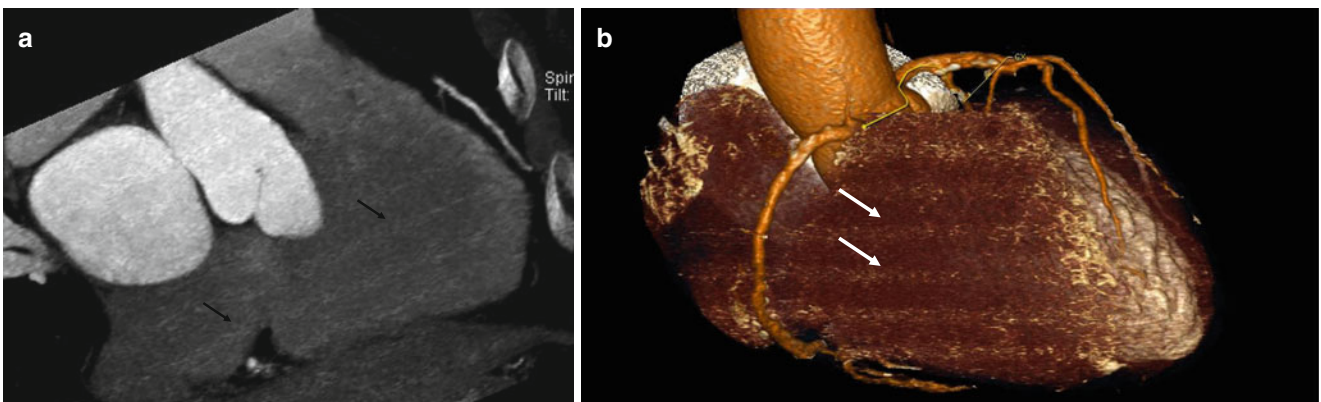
Cone-beam artifact in the 2-chamber view (a) and the volume-rendered view (b) (*arrows*)
